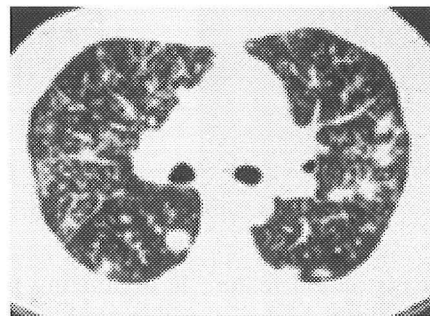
HRCT small nodular densities
